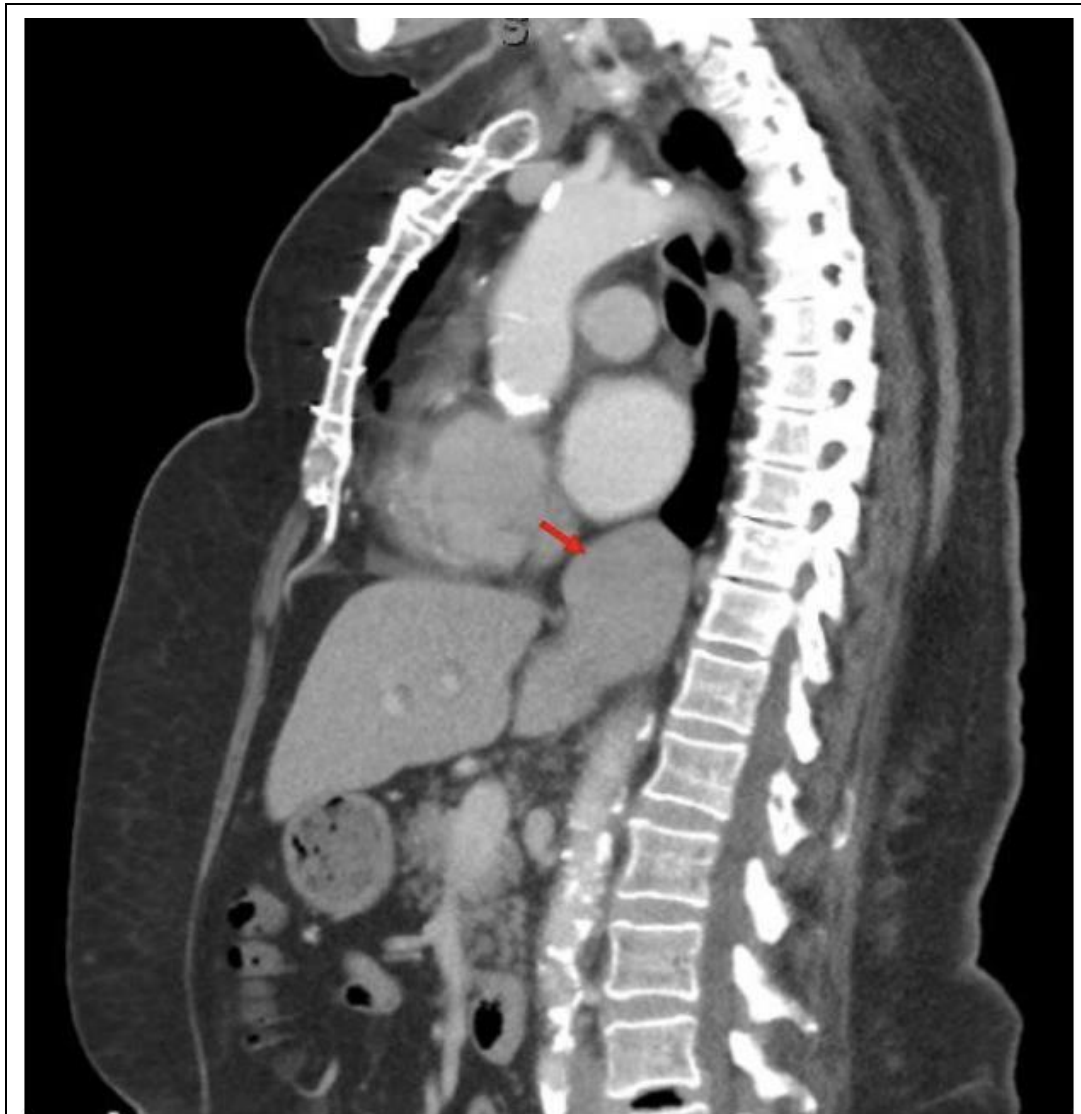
Computed Tomography of the chest, abdomen and pelvis with contrast (sagittal view) showing well defined soft tissue mass in the posterior mediastinum (red arrow) similar in attenuation to the adjacent liver and appears continuous with the caudate lobe of liver.
